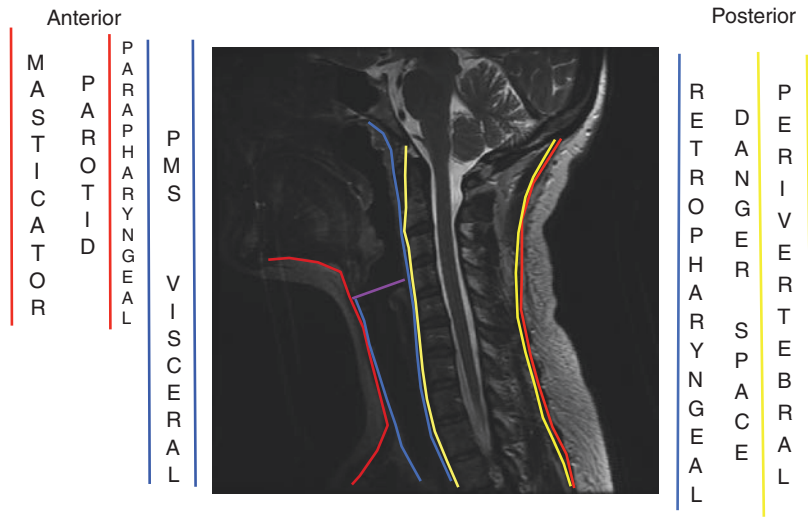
Sagittal T2W MRI of the neck. Layers of deep cervical fascia: red: superficial; blue: middle; yellow: deep
